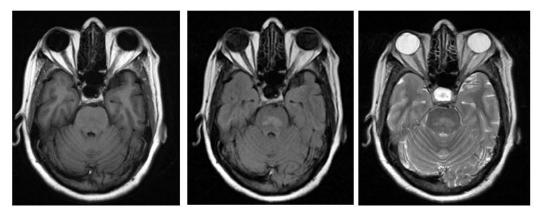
T1 hypo, T2 & FLAIR hyperintenisty in pons – s/o central pontine myelinolysis
